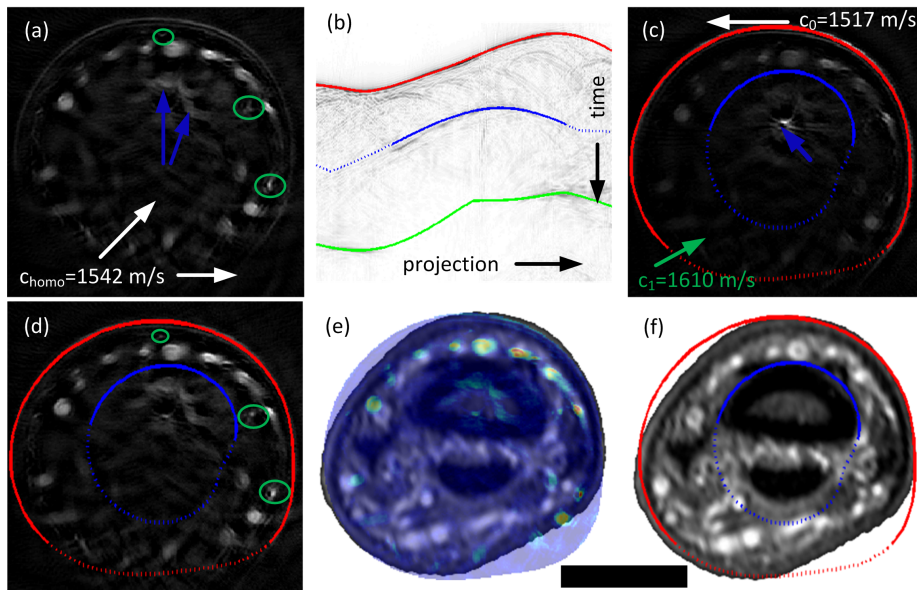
Signal domain analysis for optimized finger reconstructions. (a) Cross-sectional reconstruction of a finger at 900 nm excitation wavelength with best homogeneous SOS (1542 m/s). Blue arrows represent reflection artifacts induced by the bone. (b) Hilbert-transformed sinogram at 690 nm excitation with fits to estimate finger shape (red), inner SOS (green), and bone outline (blue). (c) Corresponding reconstruction using optimized model parameters obtained from signal domain segmentation. (d) Same reconstruction for 900 nm excitation signals with improved image quality over the homogeneous model (green circles). (e) Fusion of the corresponding MRI slice (grayscale) and the optoacoustic reconstruction (color) of (d), demonstrating the good agreement between skin and vasculature acquired with the two different modalities. (f) MRI slice with estimated skin (red) and bone (blue) location superimposed. Scale bar 1 cm.
